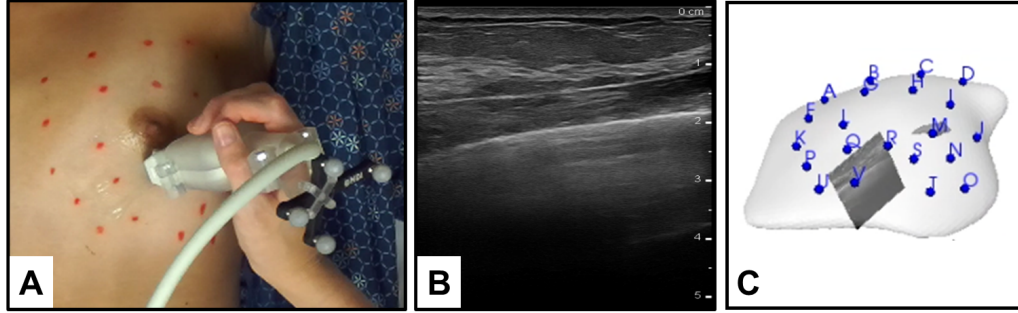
Guidance system tracked ultrasound capabilities with (A) active breast ultrasound imaging, (B) a collected B-mode image, and (C) the 3D scene view with the tracked ultrasound imaging plane.
